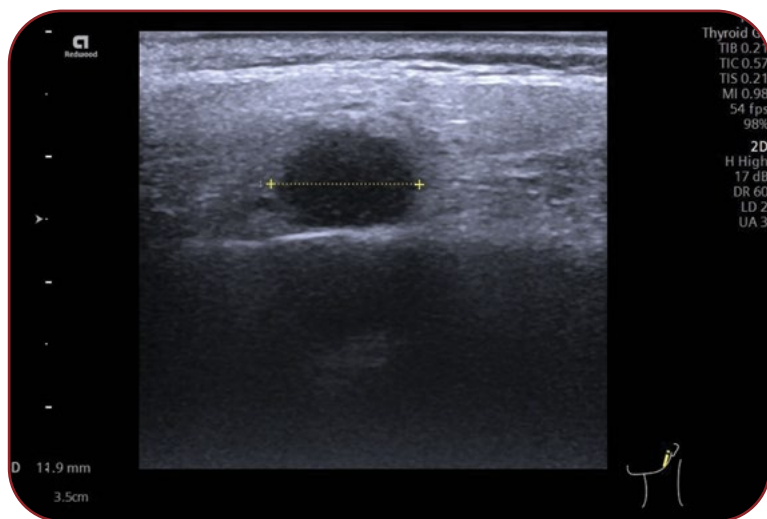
Absence of vascularity on color Doppler and relative blurred margins
